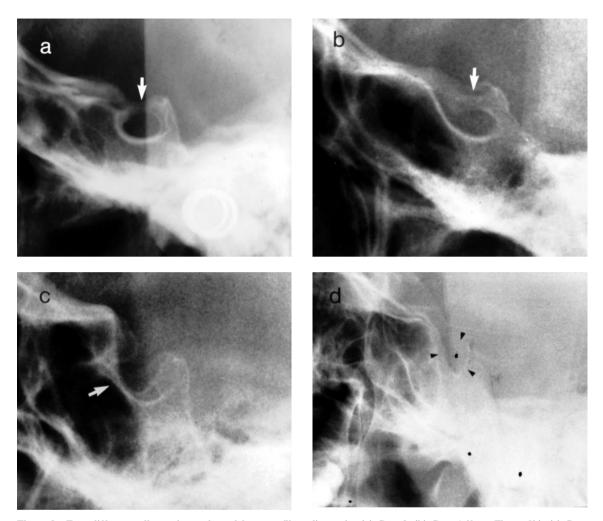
Four different sella turcicas enlarged from profile radiographs. (a) Case 2. (b) Case 4 (from Figure 8b). (c) Case 3 (from Figure 8c). (d) Case 8 (from Figure 8a). The radiographs show the presence of a sella turcica bridge in Figure 9a,b, an oblique anterior wall in Figure 9b,c, and a diminished sella turcica volume in Figure 9a (moderate) and d (severe).
